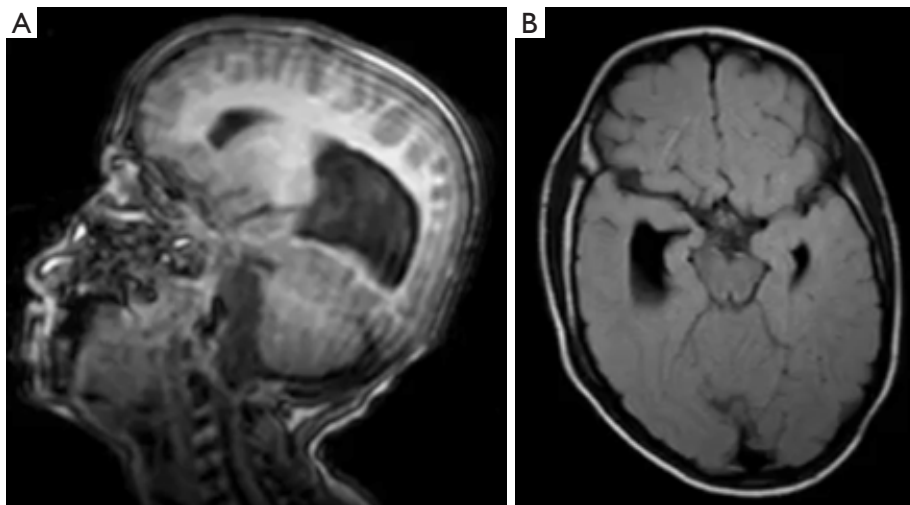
Brain MRI. Callosal agenesis with bilateral colpocephaly with temporal horn dilatation, parahippocampal atrophy, lissencephaly and midbrain hypoplasia is observed.
